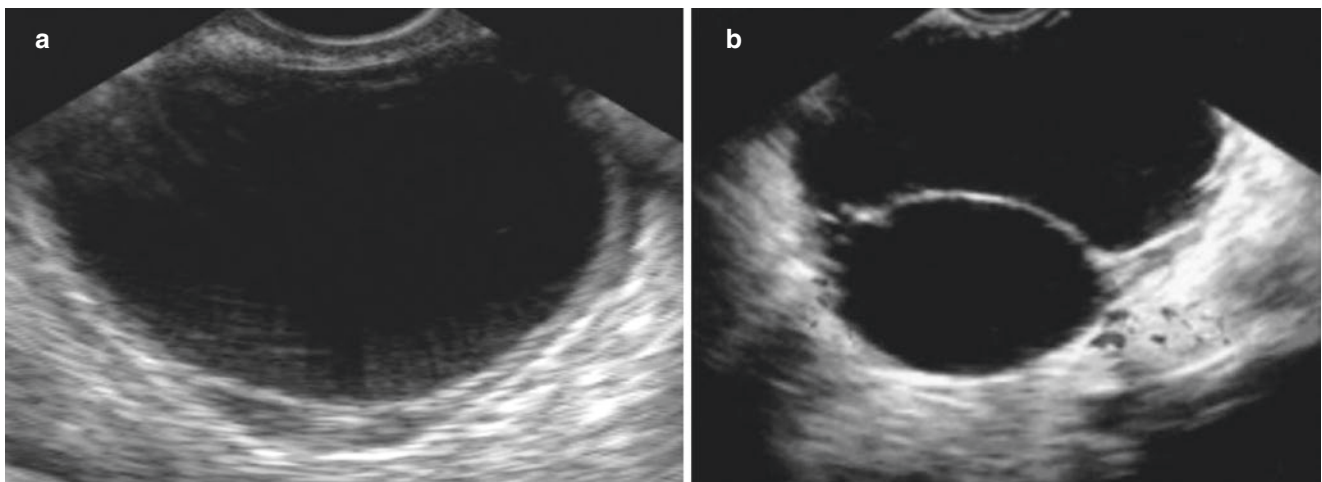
Simple ovarian cyst. (a) Sonogram shows a monolocular cyst in the pelvis, with thin capsule, clear boundary, and clear fluid inside. (b) Sonogram shows a multilocular cyst with a thin capsule and clear fluid inside
